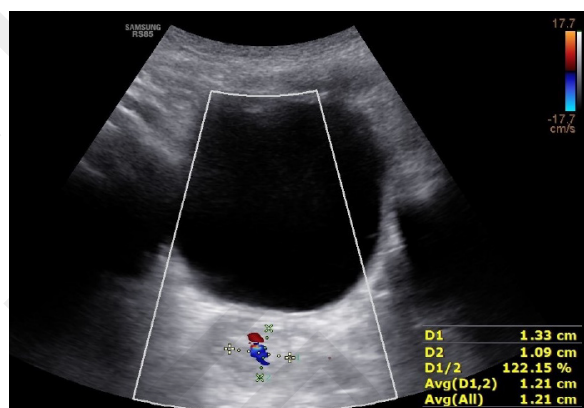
Patient No. 5. Abdominal ultrasonography revealed a solitary, well-vascularised, oval-shaped, pedunculated mass measuring 13 × 10 mm in the anus
